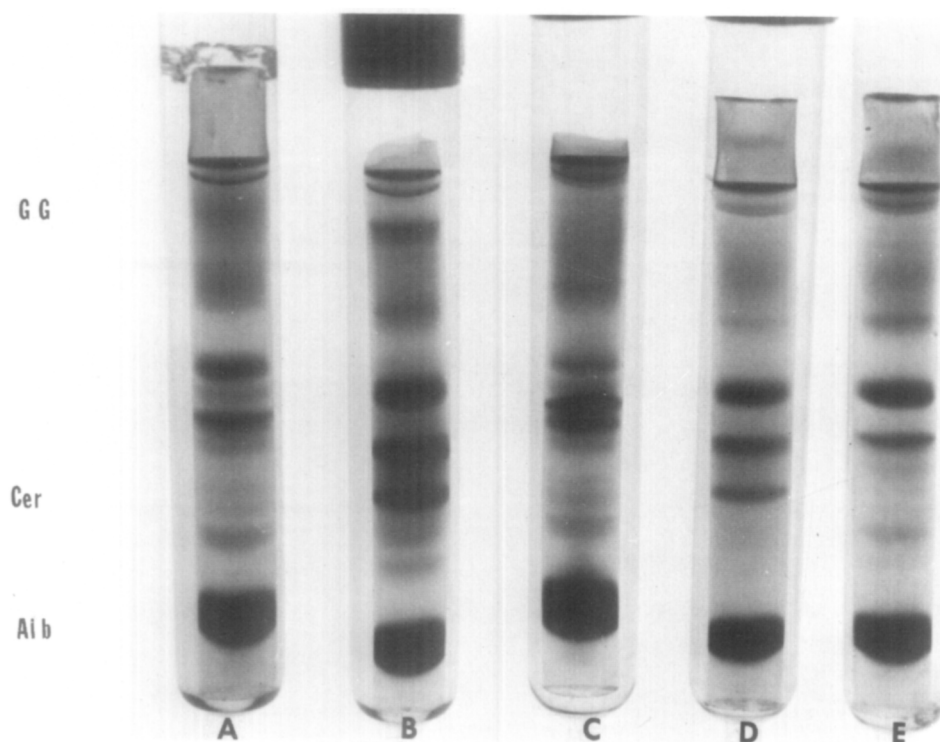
Polyacrylamide-gel electrophoretic patterns from Case 10; radicular cyst. *A*, Fingertip plasma. *B*, Periapical plasma before operation. *C*, Root canal fluid. *D*, Periapical plasma after operation. *E*, Plasma from periosteum near the apical region of normal, contra-lateral tooth.
